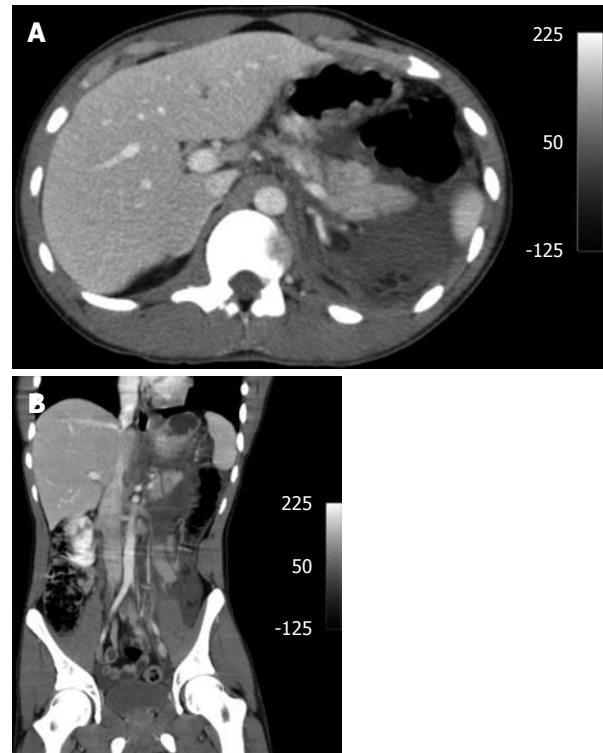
Abdominal computed tomography showing a pancreas fracture and fluid in the upper abdomen.
